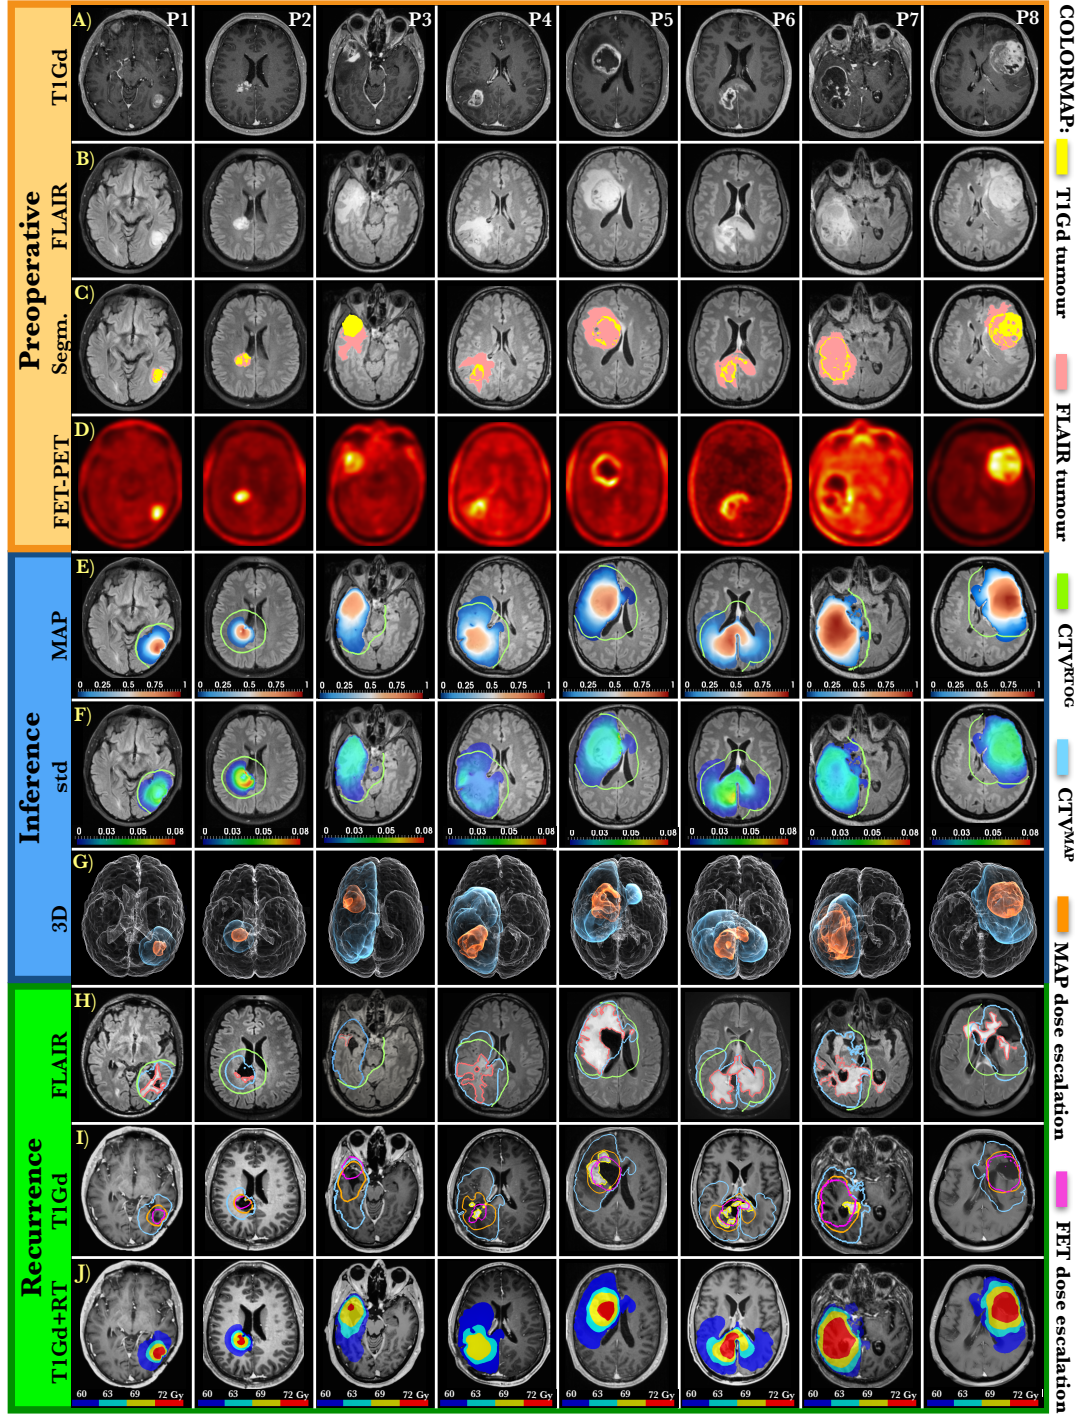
Results of the Bayesian calibration for patients $P1$ - $P8$. Orange box: Preoperative scans showing (A) T1Gd; (B) FLAIR; (C) Tumor segmentations: T1Gd (yellow) and FLAIR (pink); (D) FET-PET. Blue box: (E) MAP and (F) std of the inferred tumor cell densities shown in the preoperative FLAIR scans. The CTV^{RTOG} margin is shown as the green curves. (G) The 3D reconstructions show outlines of the MAP tumor (blue) together with tumor extent visible on the FET-PET scans (orange) in the preoperative anatomy (white). Green box: Scans of the first detected tumor recurrence. (H) FLAIR tumor recurrence (pink), CTV^{RTOG} (green), and CTV^{MAP} (blue) margins. (I) T1Gd tumor recurrence (yellow) and the dose-escalation outlines proposed by FET enhancement (magenta) and MAP estimates (orange). (J) Multilevel dose-escalation designed by MAP estimates.
